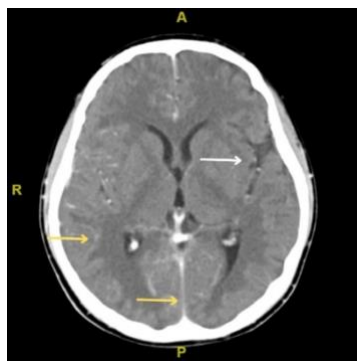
Head contrast-enhanced computed tomography (CECT) axial view showed bilateral enhancement in the sylvian fissure and ambient cistern (white arrows), as well as leptomeningeal enhancement (yellow arrow)
